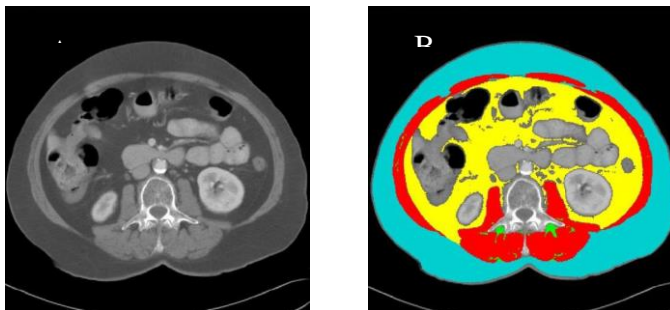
Example of selection of CT body composition fat areas using Slice-O-Matic; (A) mid-L3 vertebra axial slice from preoperative portal venous phase CT, (B) threshold selection of intramuscular adipose tissue (IMAT, -190 to -30 Hounsfield units (HU), green), visceral (intra-abdominal) adipose tissue (VAT, -150 to -50 Hounsfield units (HU), yellow), subcutaneous adipose tissue (SAT, -190 to -30 Hounsfield units (HU), blue) and skeletal muscle area (SMA, -29 to +150 Hounsfield units (HU), red) (73).
